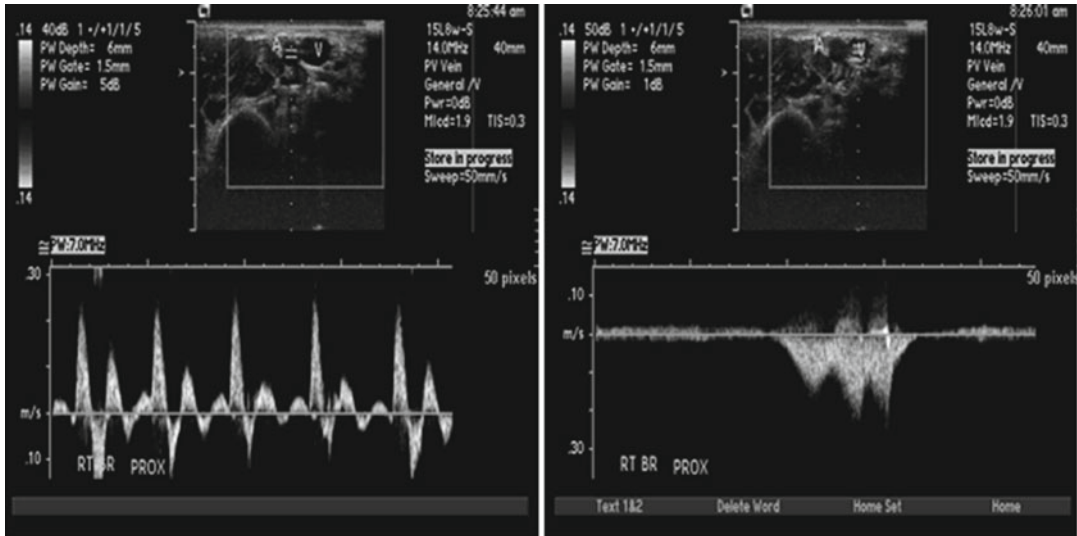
Preoperative Doppler vein mapping. Courtesy of Maria Alonso, MD, Cincinnati Children's Hospital Medical Center
